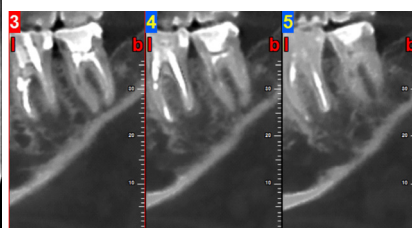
Sagittal view of CBCT revealing an IRR in mesial root of tooth 37.
